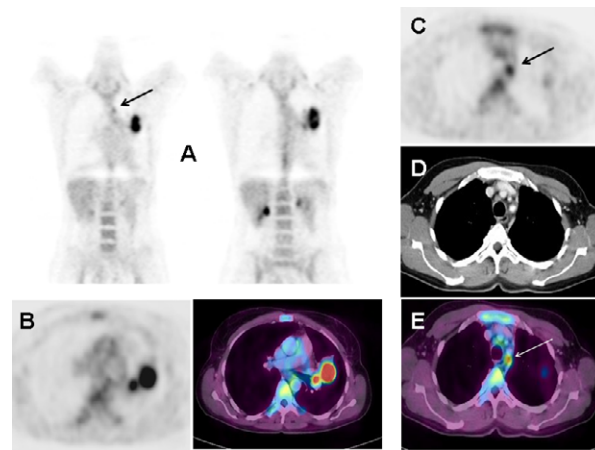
PET-CT in a patient with squamous cell carcinoma of the left upper lobe. FDG uptake is present in the primary tumour and an adjacent hilar lymph node (A, B). PET also shows a focal hot spot suspected for N2 disease in level 2L (A, C arrow). PET-CT fusion images project the hot spot in brown fat tissue (D, E). Thoracotomy with lymph node dissection confirmed the absence of mediastinal involvement (pT2N1).
